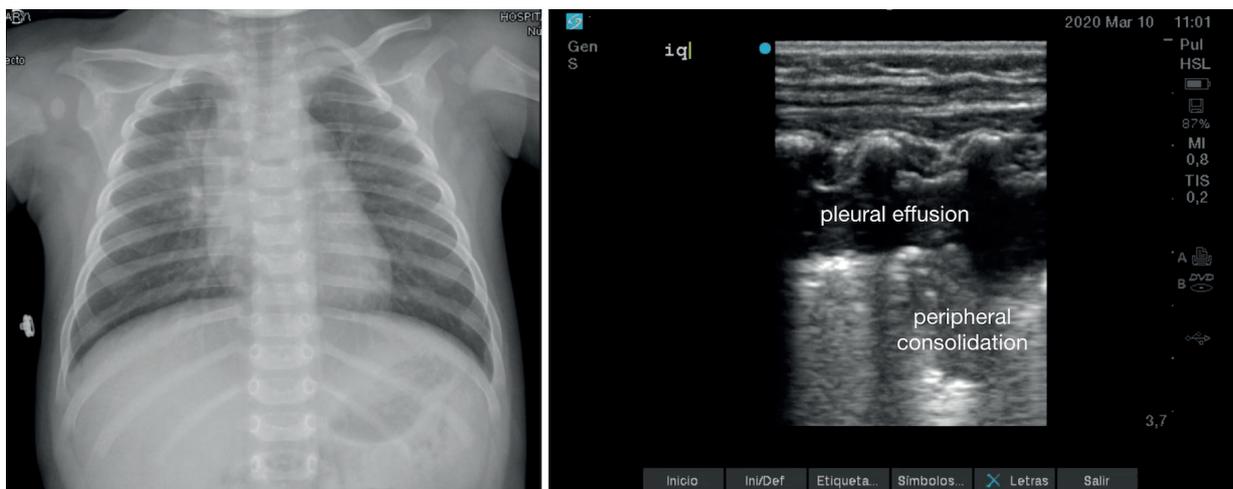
Left:* CXR showing not pleural effusion; *Right:* Lung ultrasound showing small consolidation with surrounding coalescent B-line, and pleural effusion.
